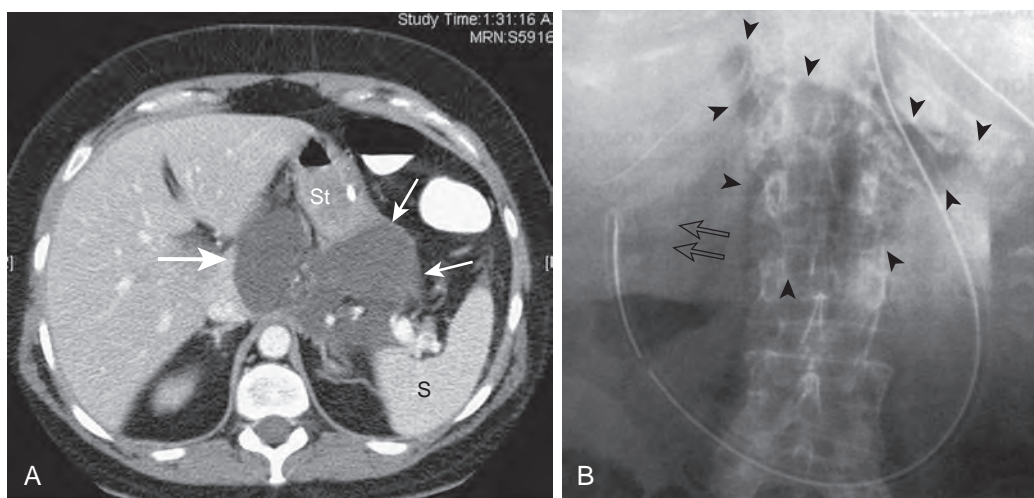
Lesser peritoneal sac. A. Axial CT scan of the abdomen in a patient with acute pancreatitis shows fluid posterior to the stomach in the lesser sac, extending into the superior medial recess (*large white arrow*). The fluid is contained on the left by the gastrosplenic ligament (*small arrows*). B. The boundaries of the lesser sac (*arrowheads*) are well delineated on a supine abdominal radiograph in another patient with gas in the lesser sac because of an abscess. The superior recess of the lesser sac extends toward the diaphragm just to the right of the spine. The foramen of Winslow is denoted by *open arrows*. A nasogastric tube is present in the stomach. S, spleen; St, stomach. (Courtesy Susan M. Williams, MD, Omaha.)
